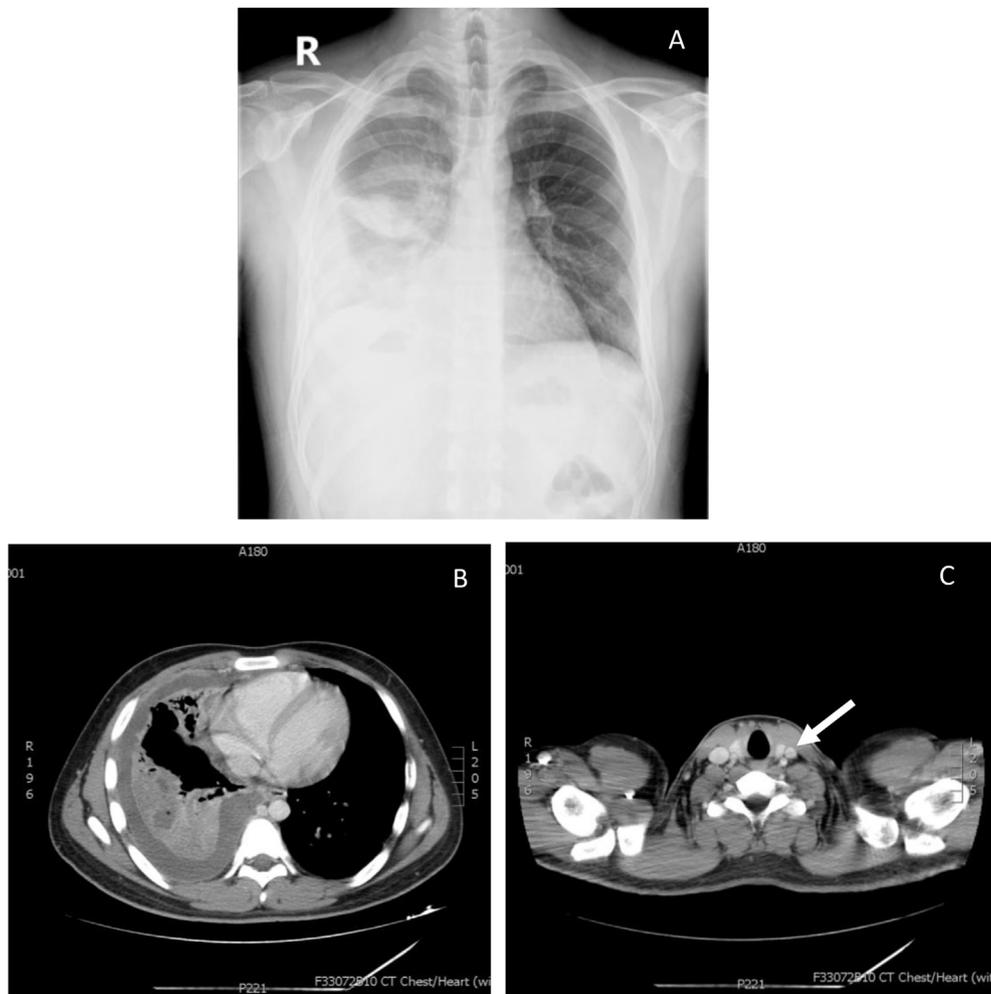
The chest x-ray and CT scan revealed infiltration, consolidation and pleural effusion of right lower lobe of lung (Fig. 1A and B). Fig. 1C showed left internal jugular vein thrombosis (white arrow site).
